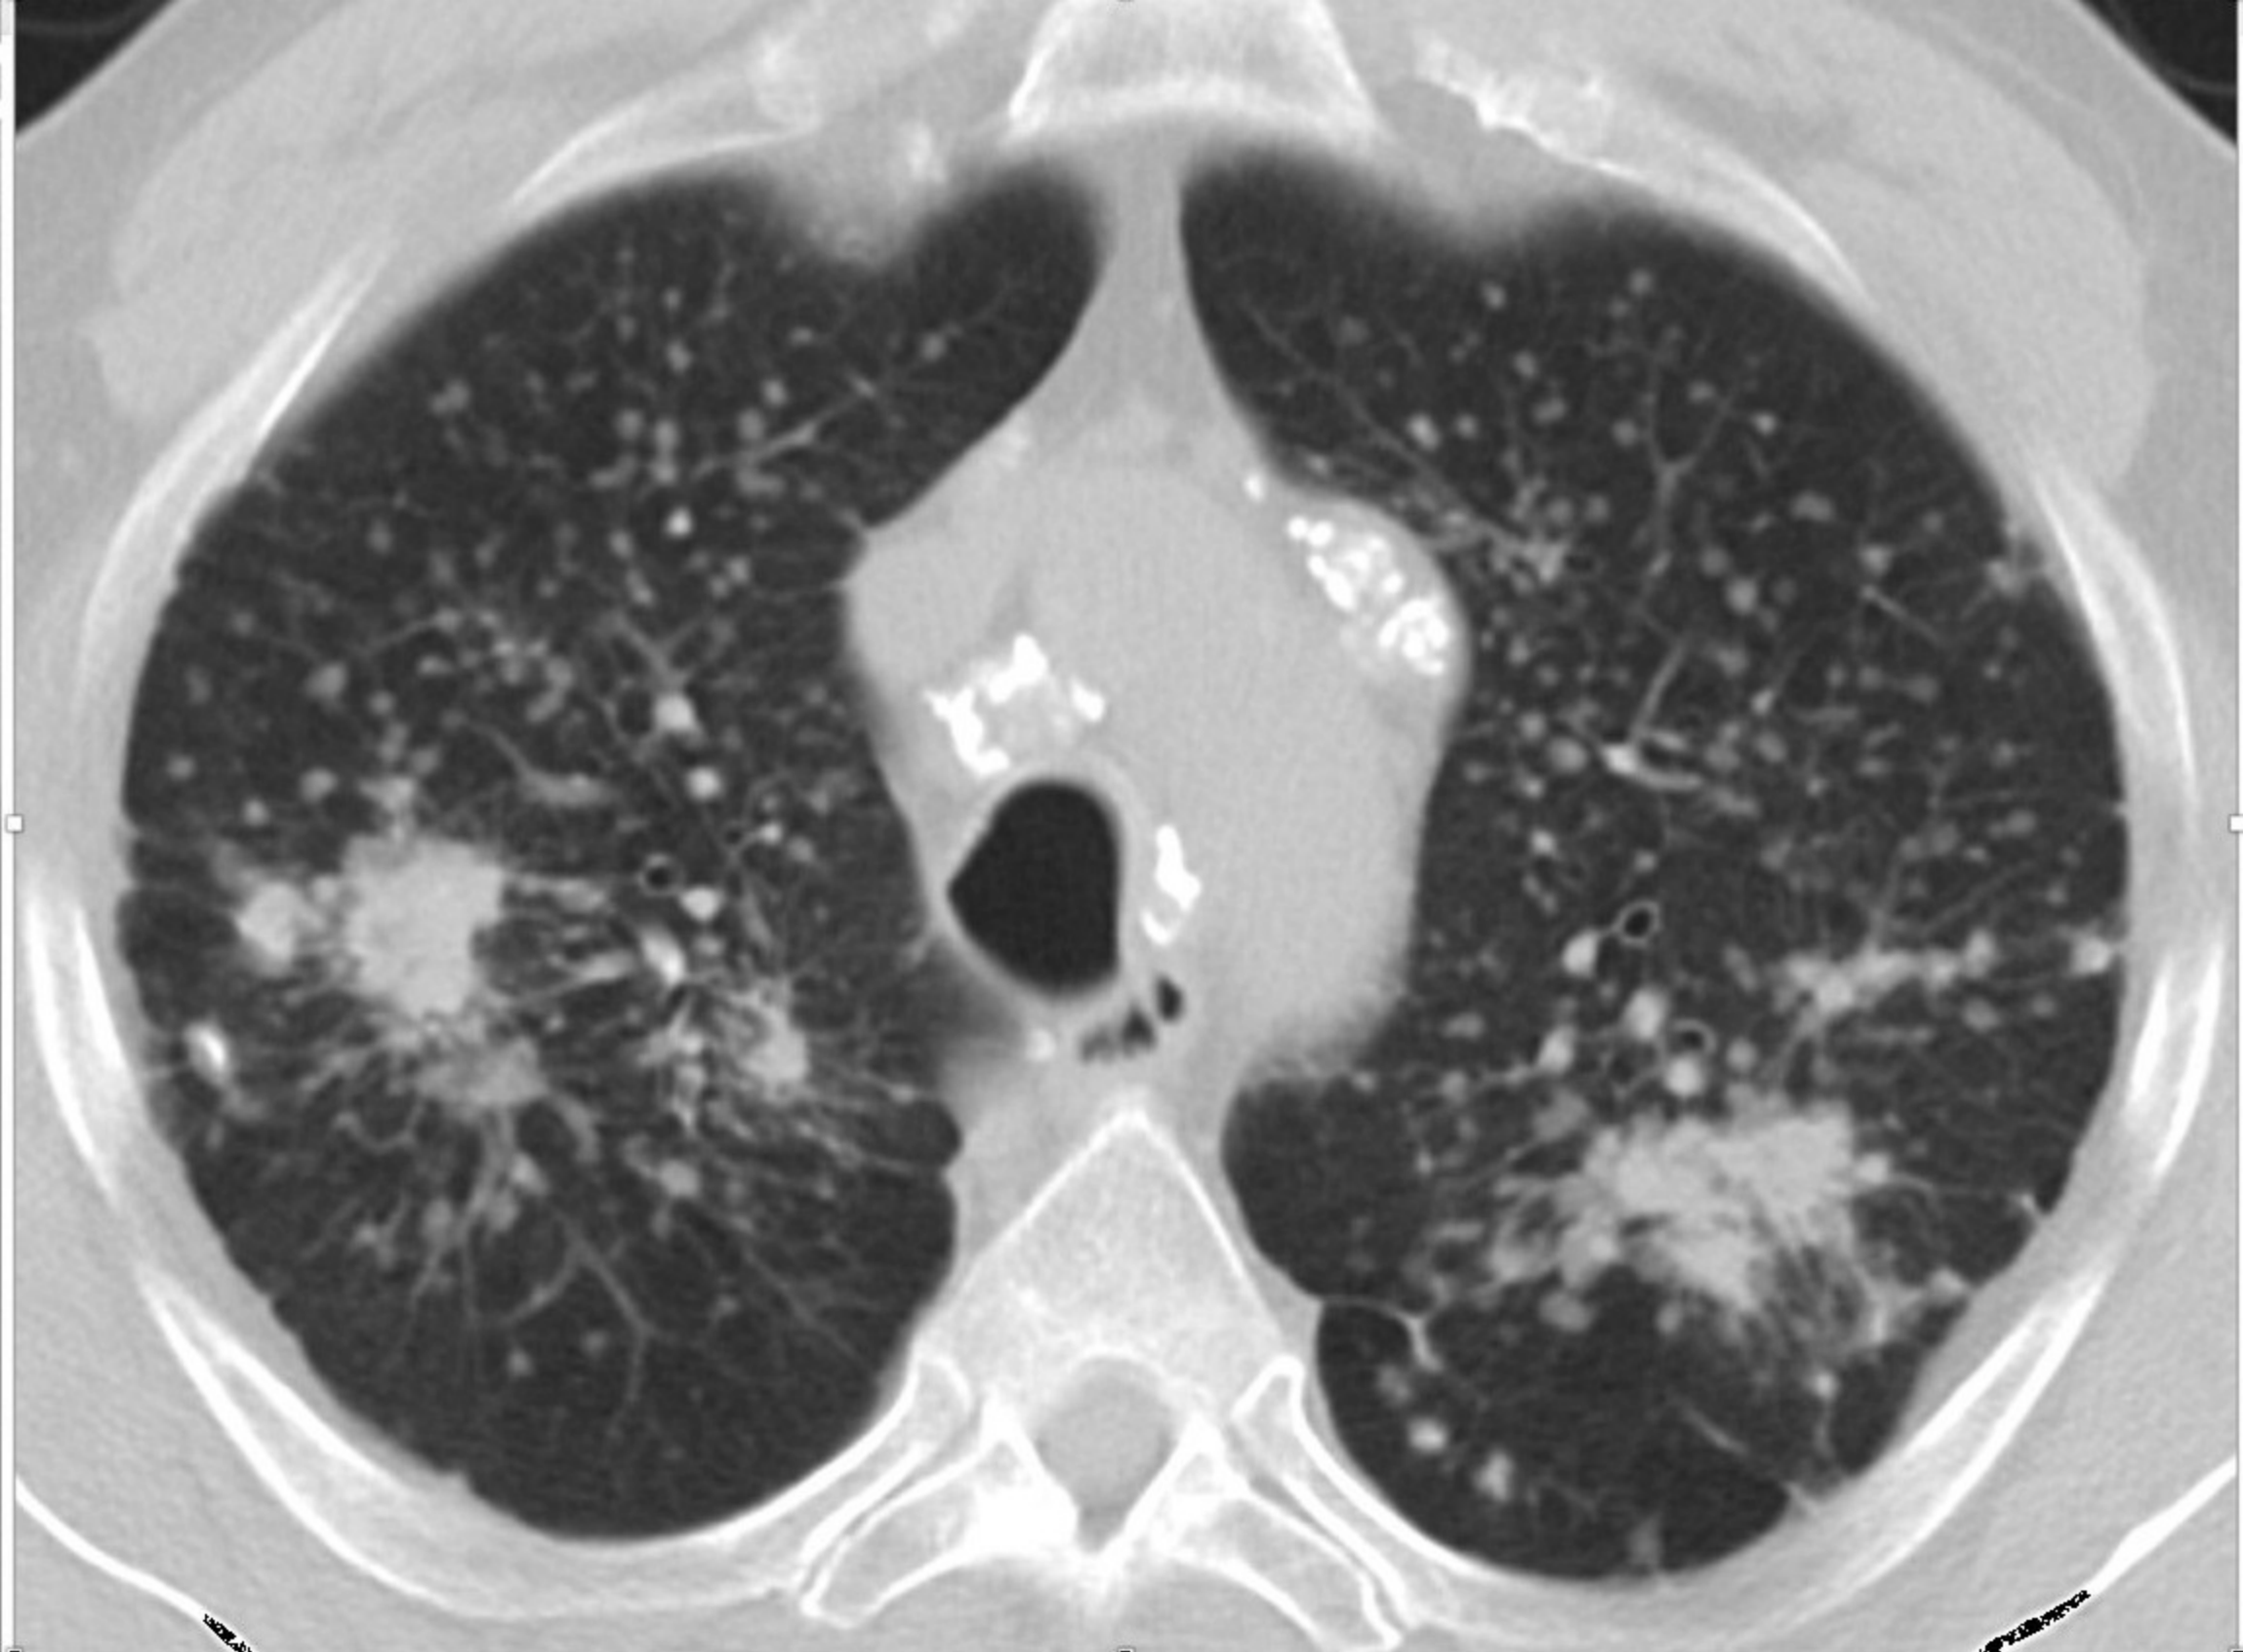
CXR and CT scan of complicated CWP which may appear similar to complicated silicosis. Note the calcifications in the mediastinal lymph nodes. The complicated lesions are seen much more clearly on the CT scan.
